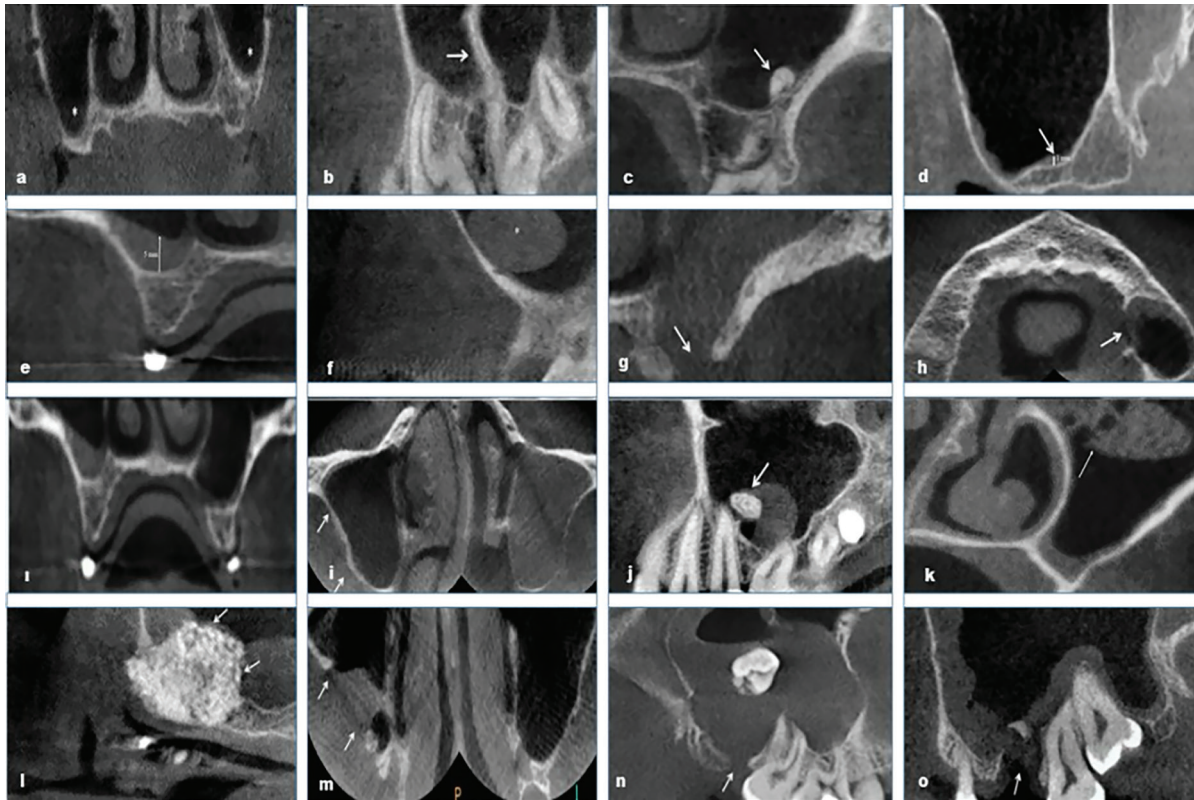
Radiographic demonstration of identified anatomical variations in the maxillary sinuses. a) Pneumatization, b) septa, c) exostoses, d) normal mucosal thickening, e) pathological mucosal thickening, f) polypoid lesion, g) interruption of the floor, h-i) interruption of the medial wall, j) lateral bone wall thickening, k) antrolith, l) fluid retention, m) foreign body, n) interruption of the lateral wall, o) ectopic tooth, p) root.
